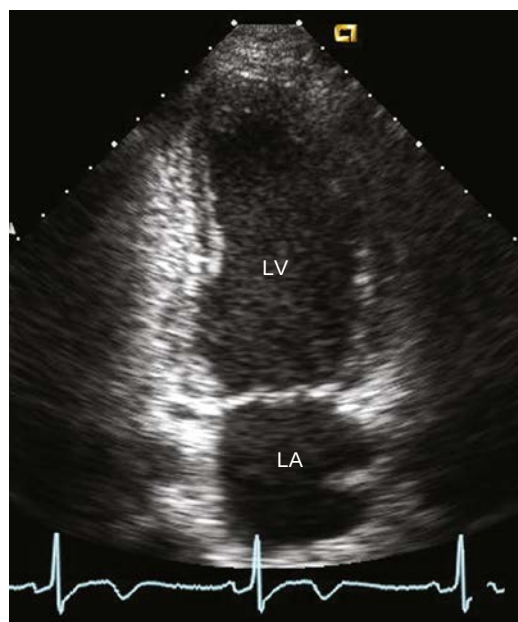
Apical 2-chamber view. This view is obtained by rotating the transducer about 60° counterclockwise from the 4-chamber view.
